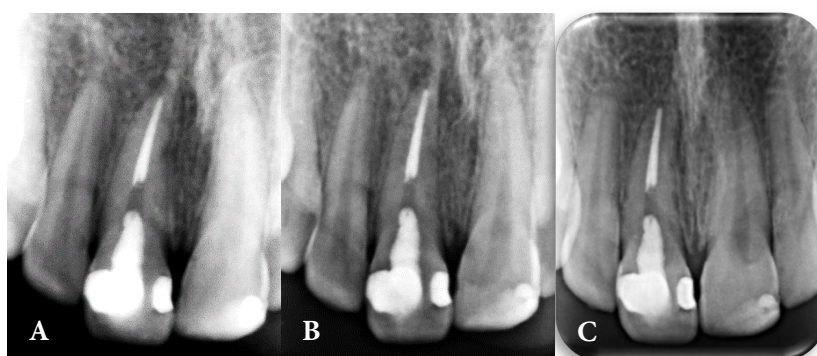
Periapical follow-up radiographs of tooth at A) 6-month; B) 14-month; C) Five-year
